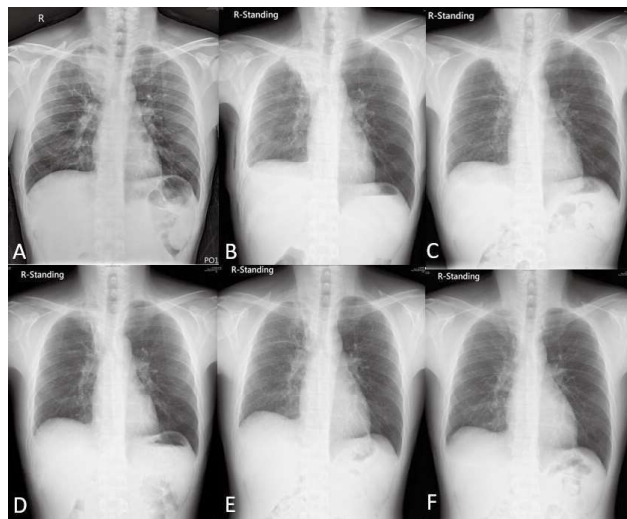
The right upper lung soft tissue mass showed improvement on chest X-ray during follow-up. (A) Day 1 of hospitalization; (B) Day 32 of hospitalization; combination antimicrobial treatment for nocardiosis started at this point; (C) Day 44 of hospitalization; trimethoprim-sulfamethoxazole discontinued; (D) Day 101 of hospitalization; intravenous antimicrobial treatment switched to oral antimicrobial; (E) 12-week antimicrobial treatment completed; (F) Outpatient department follow-up 1 year later.
